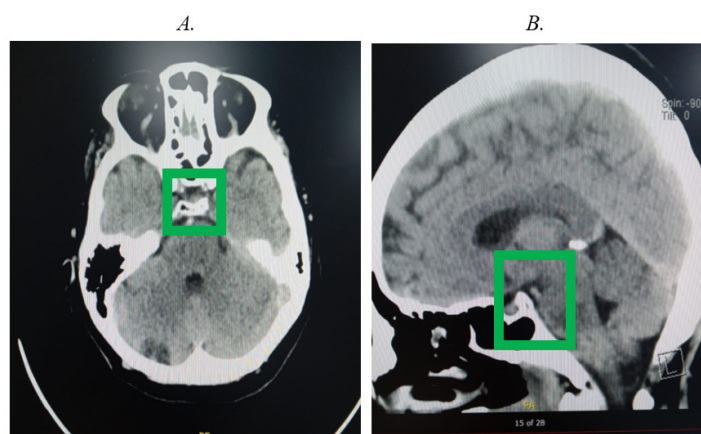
Simple skull CT. A. In the axial plane, a hyperdense point in the course of the basilar artery is seen in the frame. B. In the sagittal plane, hyperdensity of the basilar artery and hypodensity of the pons is observed in the frame.
